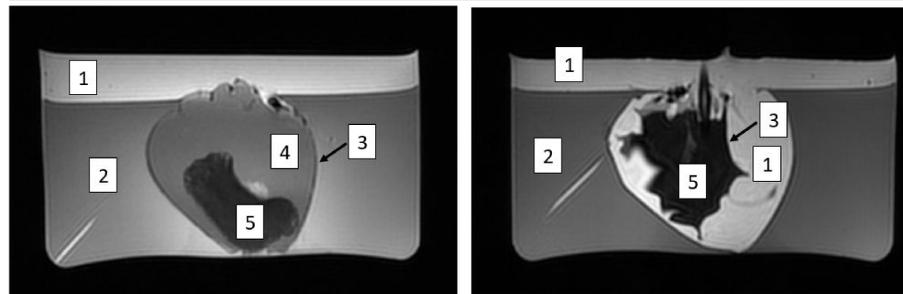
MR image of prototype before clot aspiration (left) and after aspiration (right). Hydrogel(1) filling in the void as plasma aspiration is visible. Materials of the images are as following :
